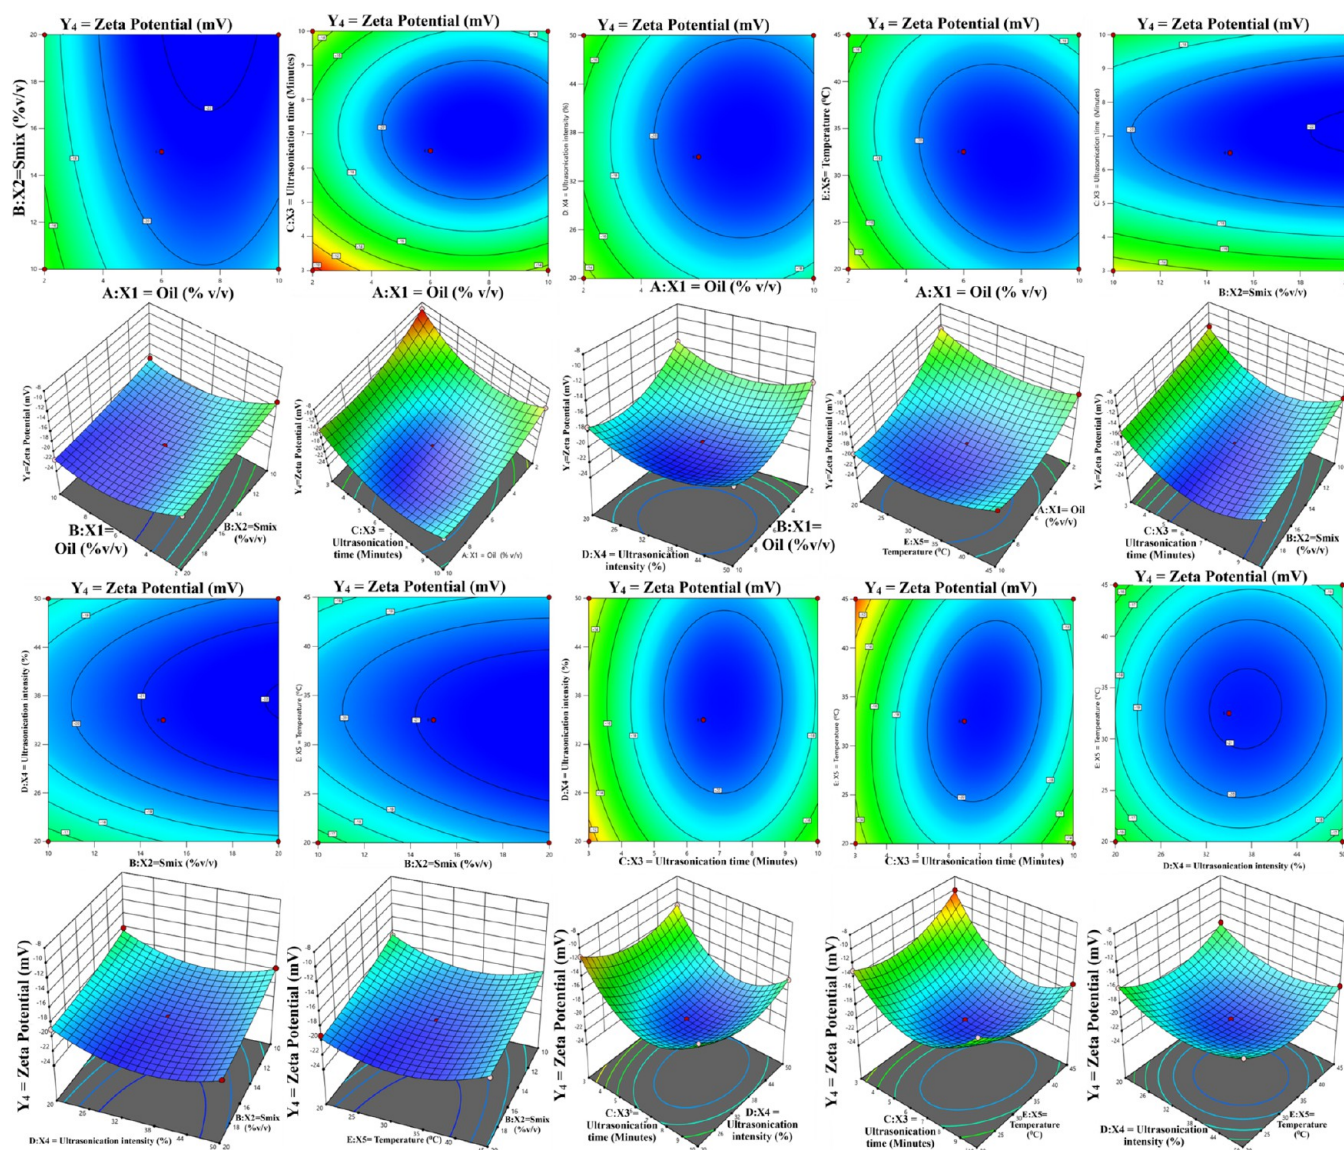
Effect of Capryl 90: oil phase (A), Smix (B) [Tween 80: surfactant, PEG 400: cosurfactant], and ultrasonication speed (C) on zeta potential (mV) (Y_4).
